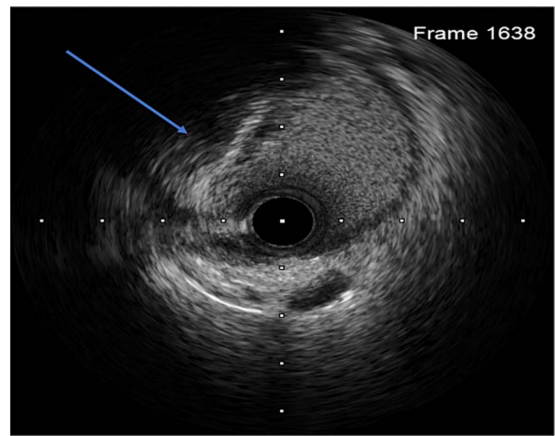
Intravascular ultrasound (IVUS). Features of thrombus (arrow).
